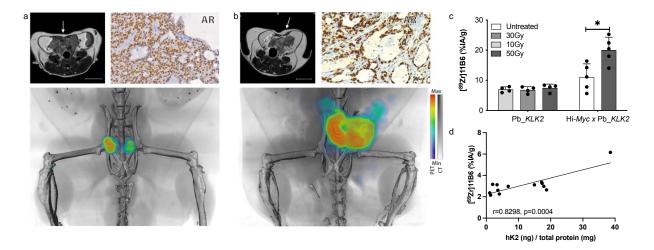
AR activity increase following EBRT visualized by [89Zr]11B6-PET/CT.
